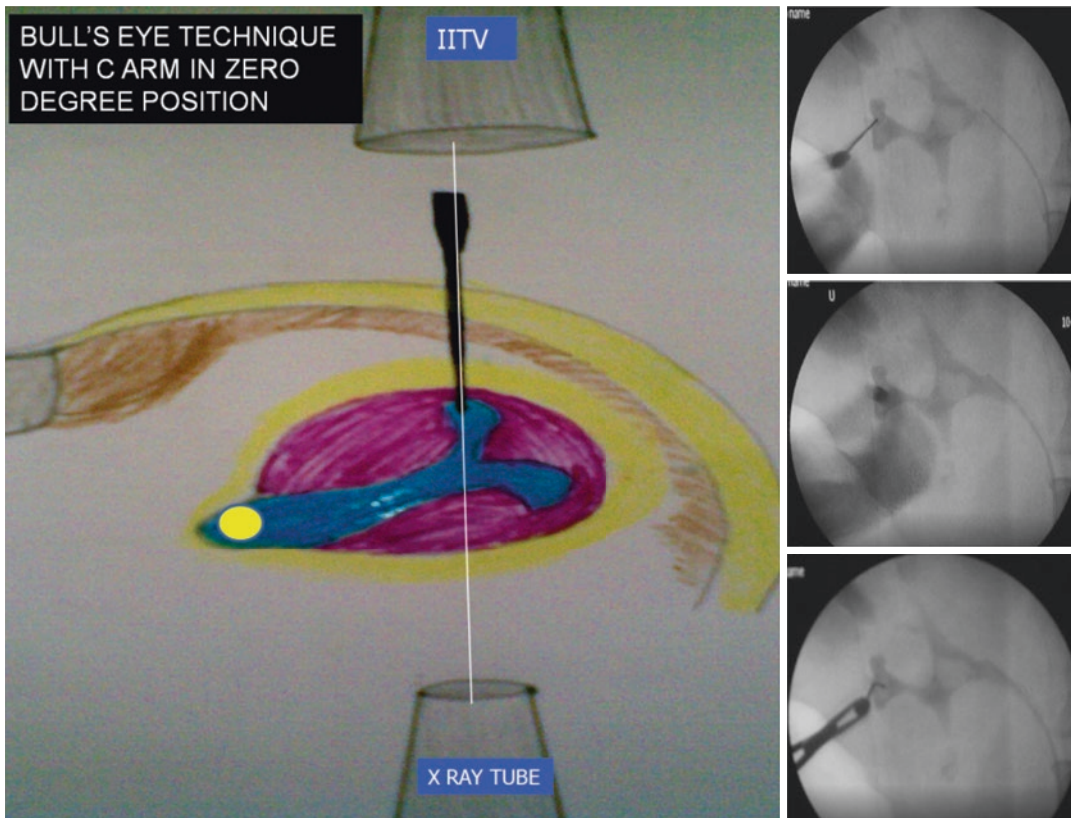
In bull's eye technique, the surgeon is expected to maintain the needle tip, whole length of the needle, and the needle hub in same straight line between the X-ray tube and image intensifier and therefore superimposed on
